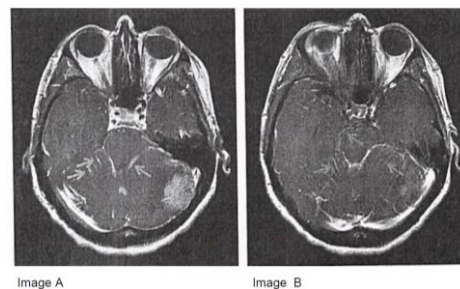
Axial T1 – weighted MRI indicating a parenchymal brain metastasis (image A) as well as leptomeningeal enhancement coating the brainstem (image A) and cerebellar folia (image B), consistent with leptomeningeal metastasis.
